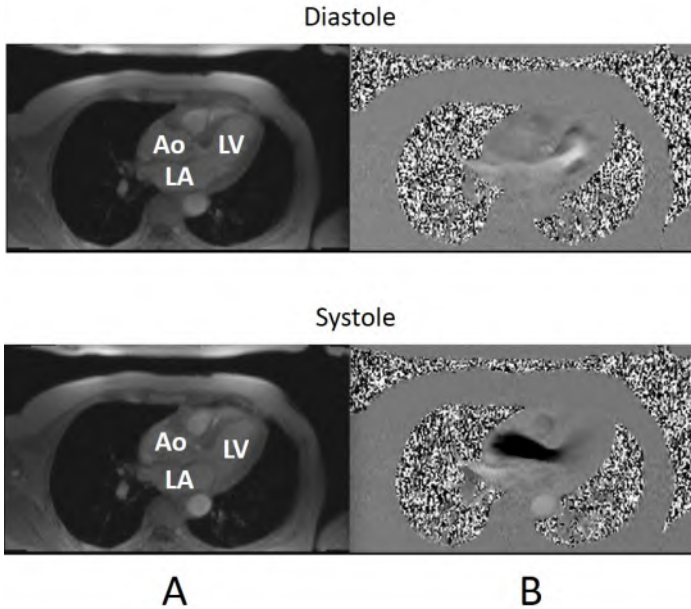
In-plane phase contrast MRI interrogations of intraventricular flow velocities in a 3-chamber view of the heart during diastole and systole. For each cardiac stage, panels show A) Magnitude data; B) Phase data. In the magnitude data, cardiac chambers are identified as LV: left ventricle; LA: left atrium; Ao: aorta. Figure adapted from [13].
